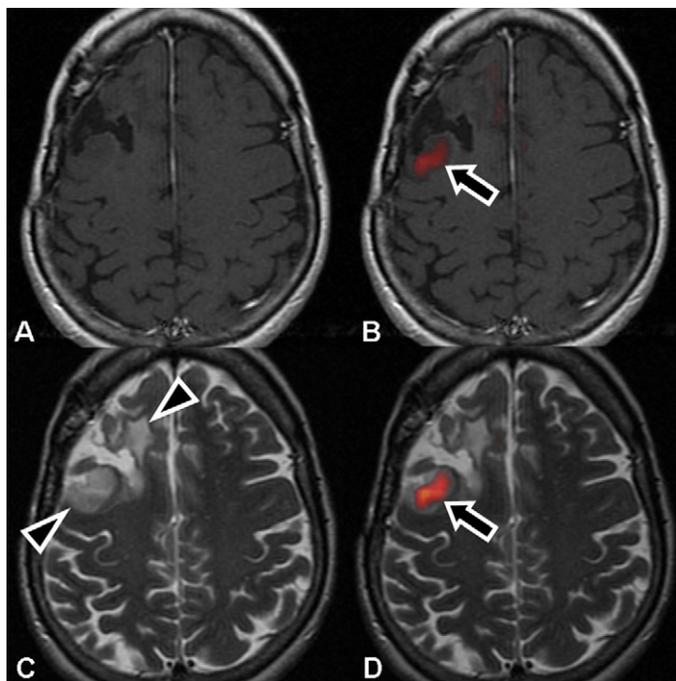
Non-enhancing tumor regions on contrast-enhanced T1W MRI (A) show high  $^{18}\text{F}$ -FDOPA activity on the fused images (B, arrow) posterior to the resection cavity, without associated contrast enhancement. There is T2W signal abnormality anterior and posterior to the resection cavity (C, arrowheads), but only the region of T2W signal posterior to the resection cavity demonstrates abnormal  $^{18}\text{F}$ -FDOPA activity (D, arrow). This region was resected and confirmed to be recurrent tumor.
